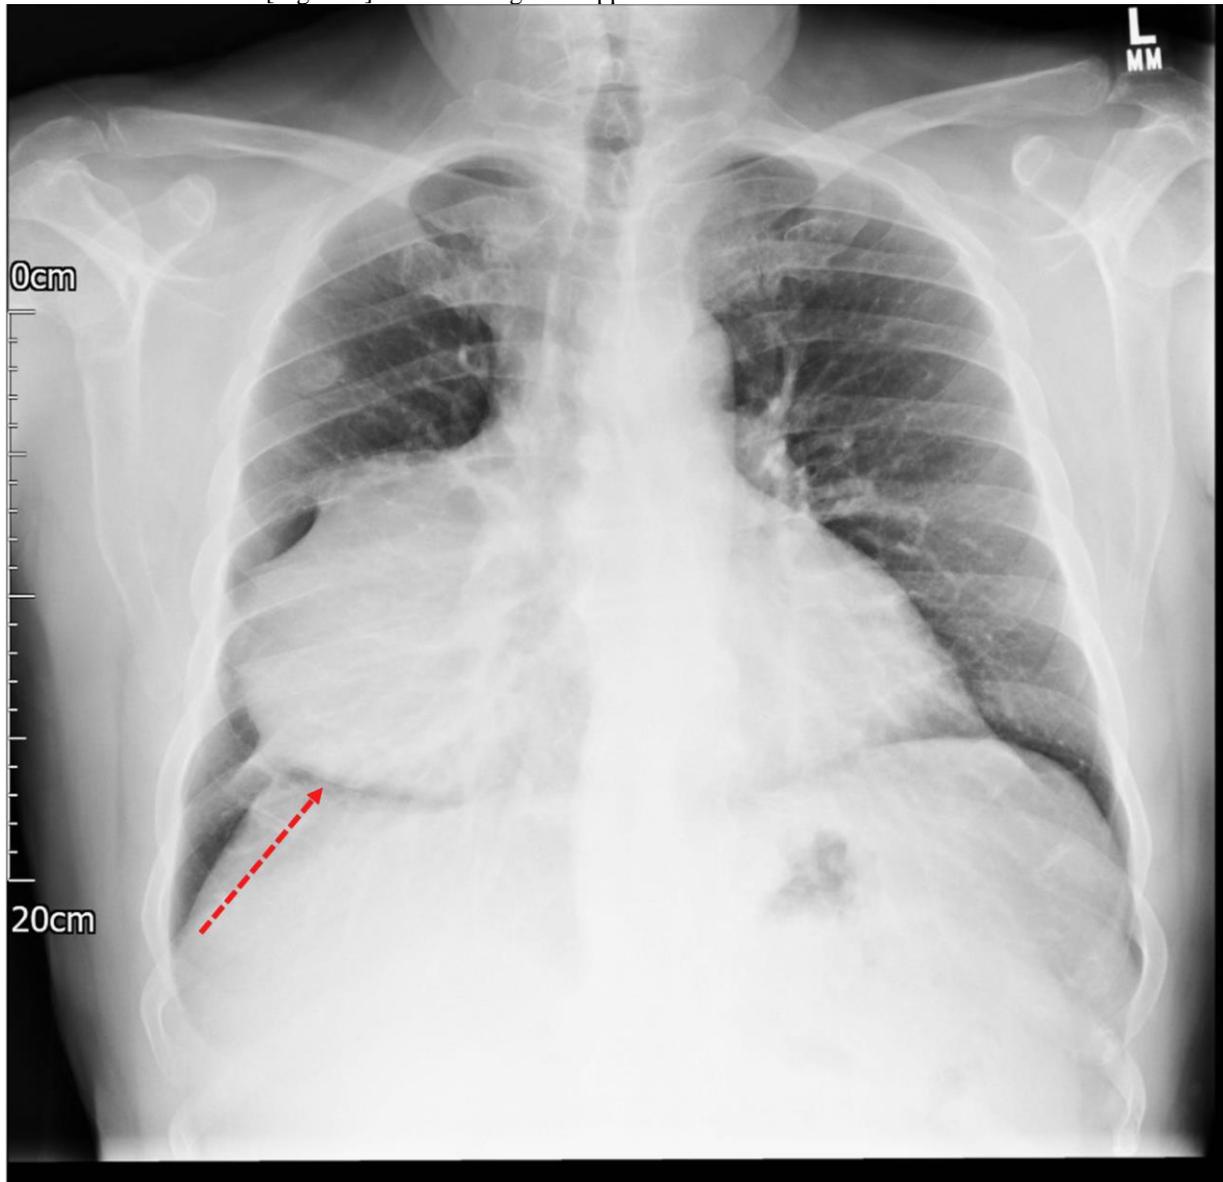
Chest X-ray showing a large, para-cardiac opacity within the right hemithorax.
